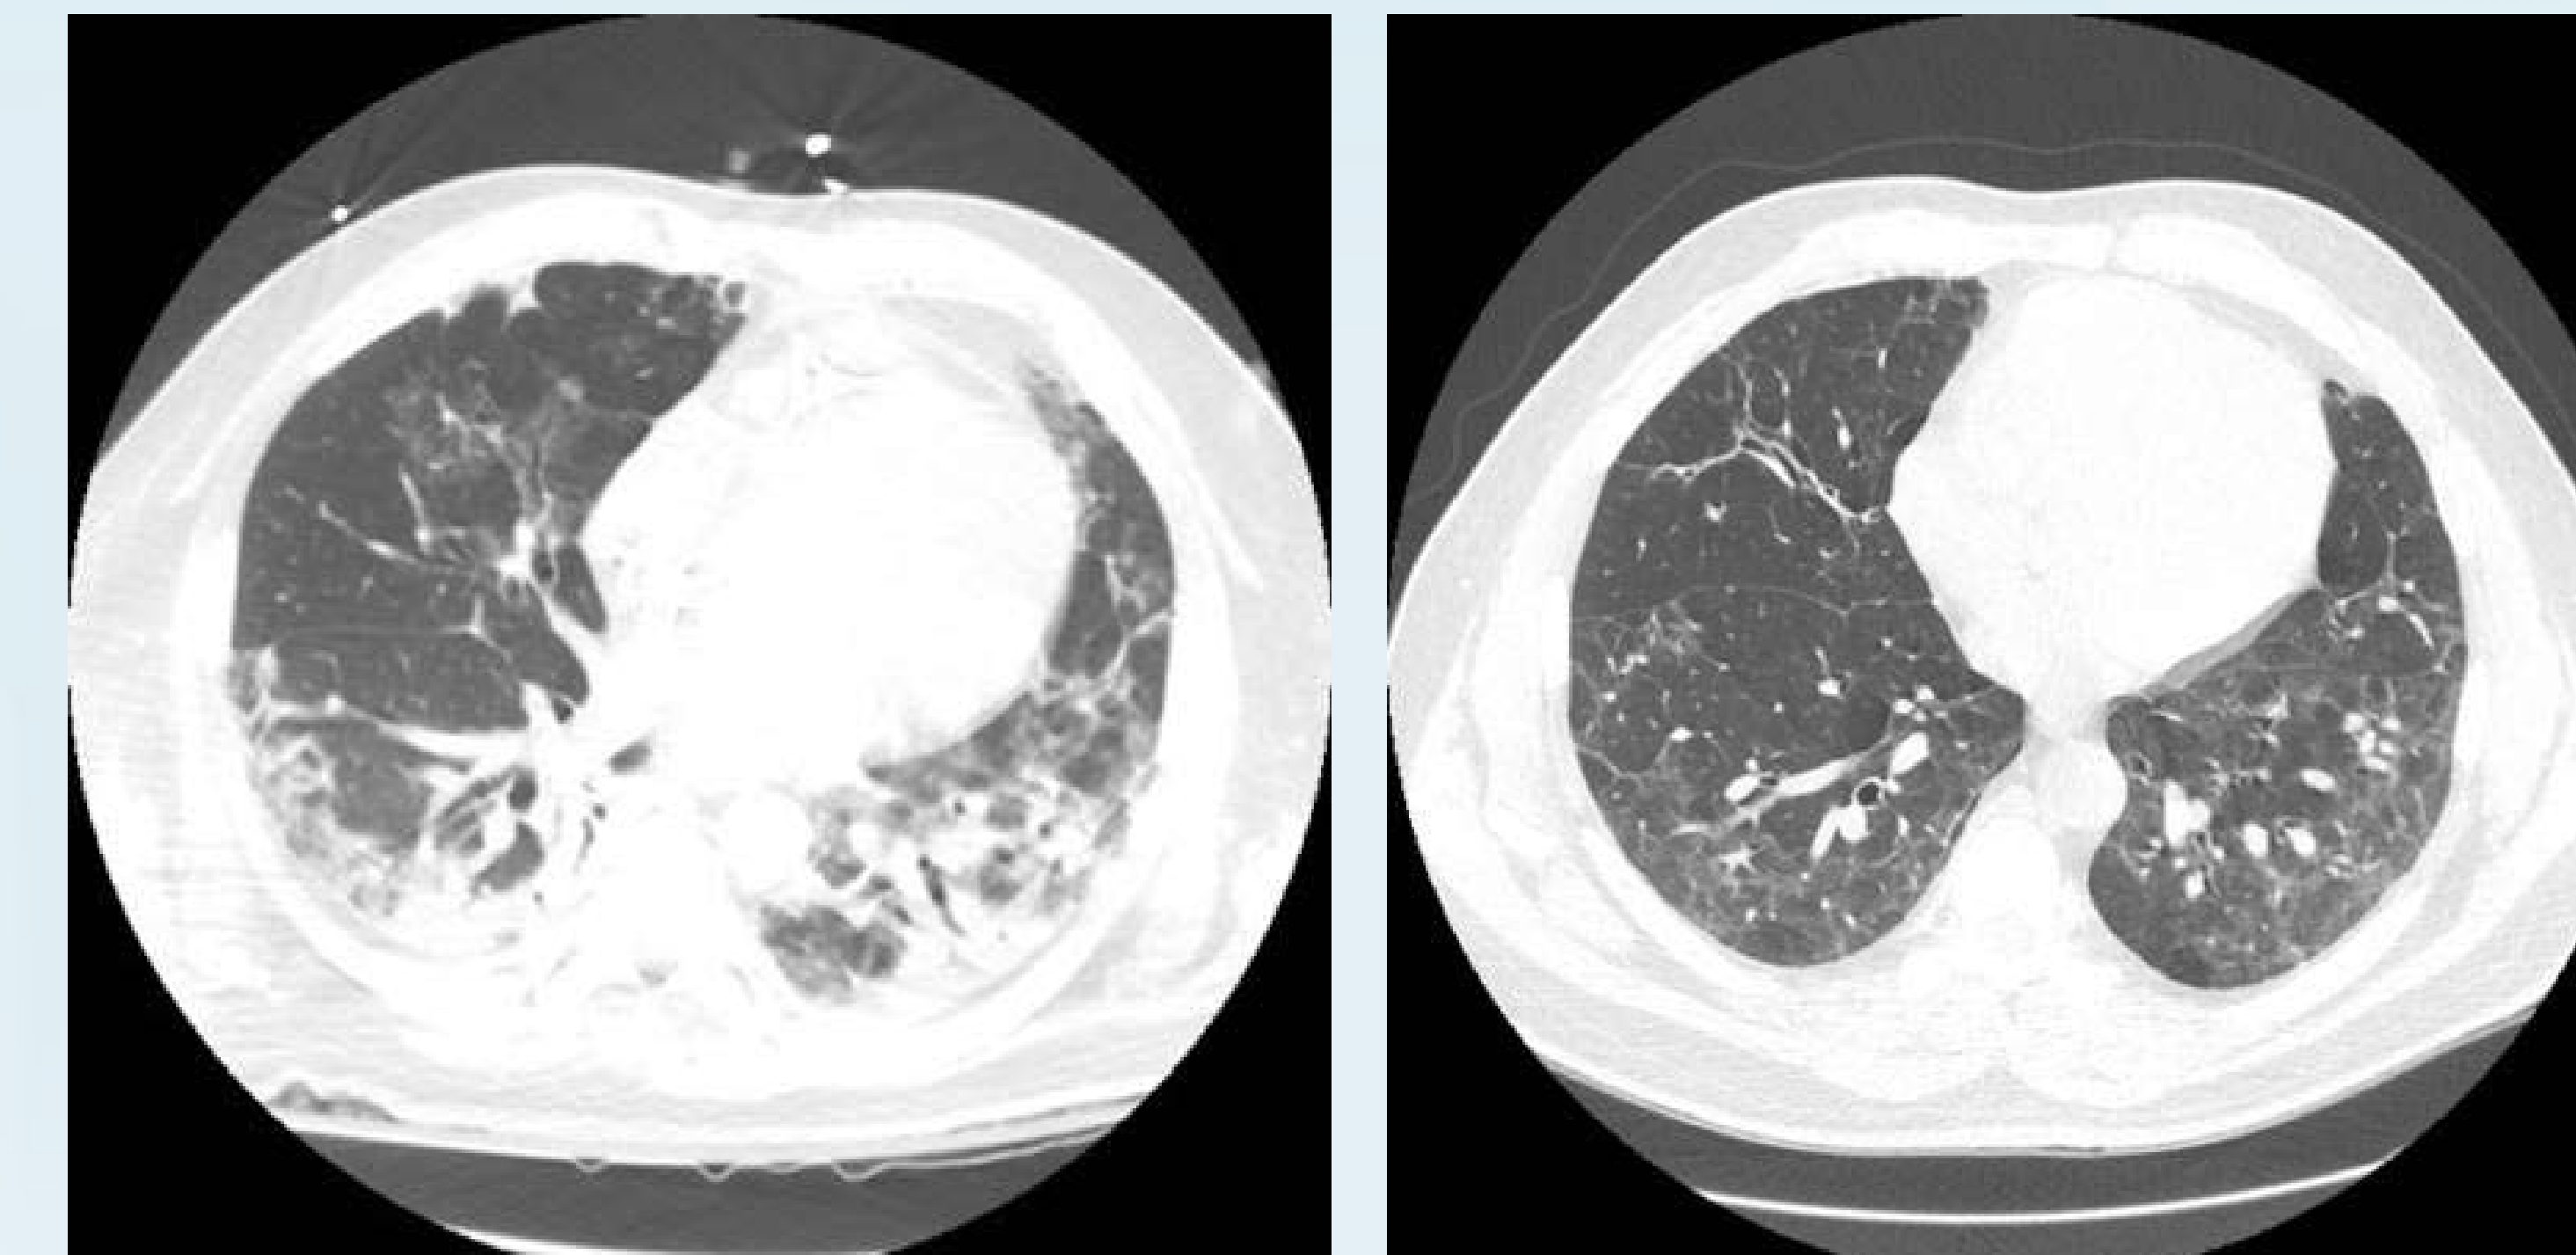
(Patient D) 50 year old male with unknown etiology for ARDS initial chest CT scan on left side. The follow up chest CT scan 225 days post ECMO is on the right side.
